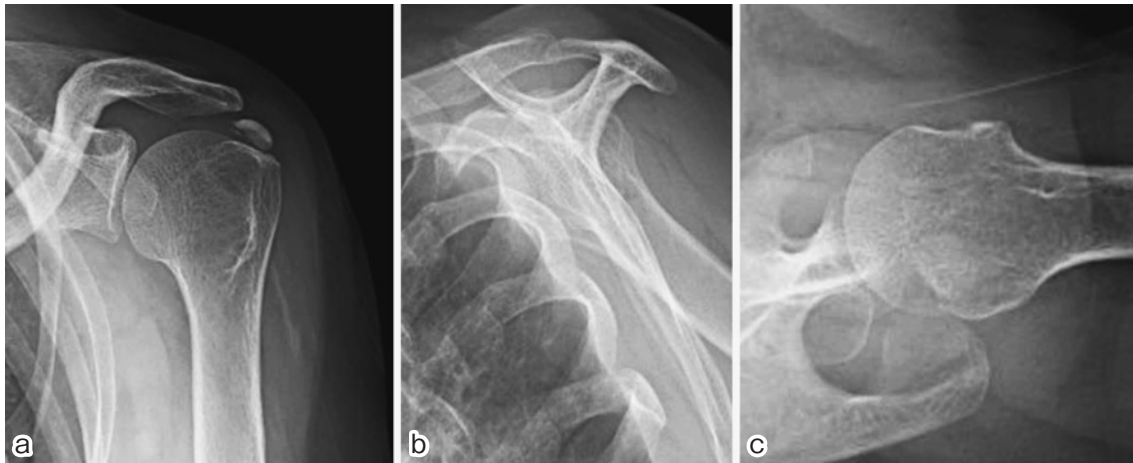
Preoperative radiographs of the left shoulder (a: AP view, b: scapular Y view, c: axial view) show a large calcium deposit.
